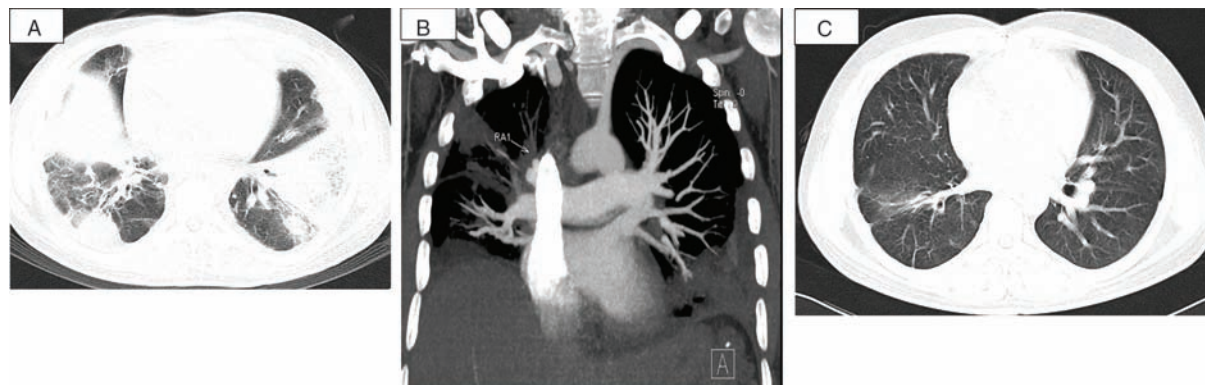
A 33-year-old male intravenous drug abuser suffered from SPE after catching a cold. The chest CT showed multiple patches, ground-glass opacities and consolidation in each lung and bilateral pleural effusion (A). Multiple pulmonary embolisms were detected in his CTPA (B). After treatment with surgery and antibiotics, the repeated chest CT showed significant improvement (C). CT=computed tomography, CTPA=CT pulmonary angiography, SPE=septic pulmonary embolism.
